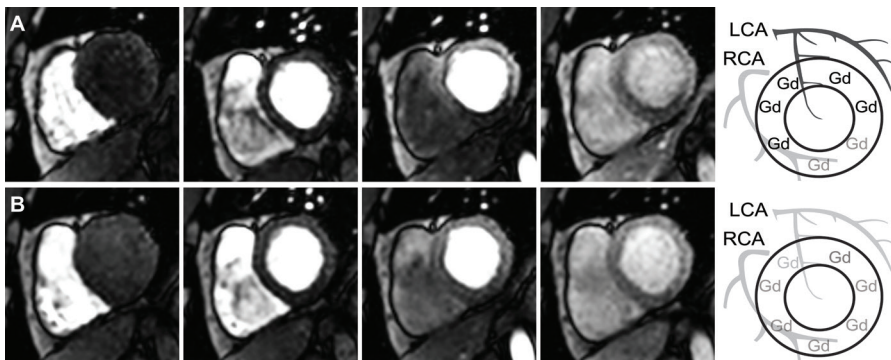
Example of first-pass adenosine stress and rest perfusion cardiac MRI: a 57-year-old man with a significant perfusion deficit in the inferior segments. (A) Dynamic adenosine stress perfusion MR images (dosage of gadoterate meglumine [Dotarem]: 0.1 mmol/kg). In contrast to the left coronary artery (LCA), the stenotic right coronary artery (RCA) cannot further dilate in response to stress, which results in pronounced hypoenhancement of the inferior segments. (B) Dynamic rest perfusion MR images (dosage of gadoterate meglumine [Dotarem]: 0.1 mmol/kg). The differences in perfusion between the inferior segments and the other segments are less pronounced. The impaired blood flow in the stenotic RCA during stress is largely restored by vasodilation in rest.
